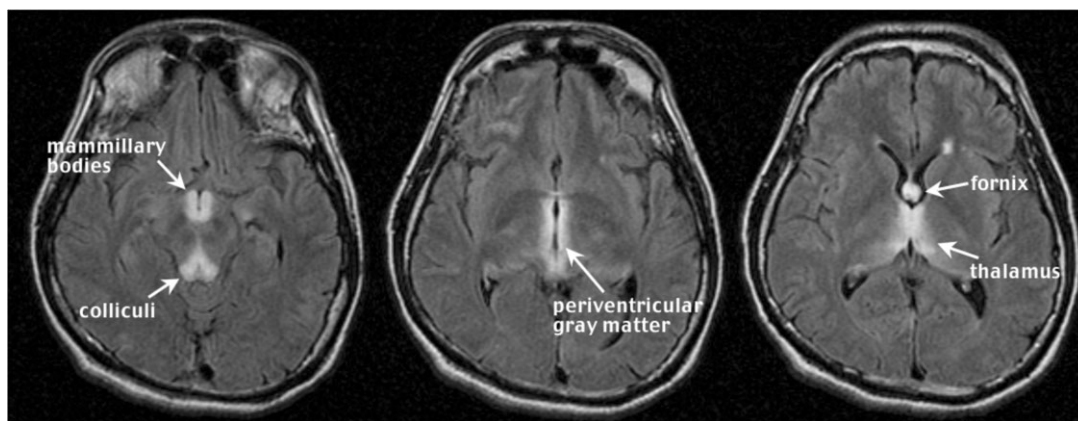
Three contiguous FLAIR images (5 mm thick with a 2.5 mm skip) of the acute WE case in Fig. 1. Note the hyperintense signal in the mammillary bodies and colliculi (left), periventricular gray matter (middle), and fornix and thalamus (right).
